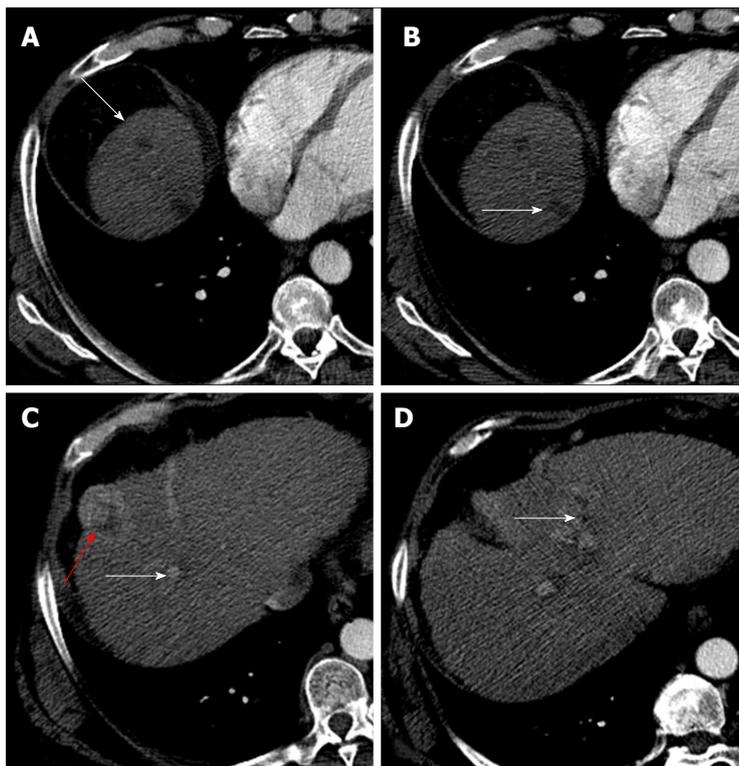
Enhanced computed tomography control after degradable starch microspheres transcatheter arterial chemoembolization shows a complete response of 4/5 lesions in well downstaged patient. After degradable starch microspheres transcatheter arterial chemoembolization patients had a new-Milan-criteria score of 4. A: Complete response of hepatocellular carcinoma (HCC) nodule on VIII segment; B: On VII segment (white arrows); C and D: Partial response of HCC nodules (red and white arrows).
